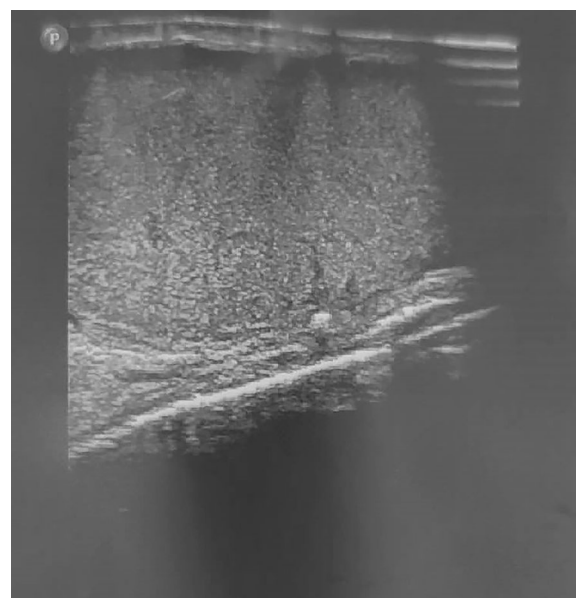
Ultrasound scan shows ill-defined, hypoechoic lesion with internal vascularity
